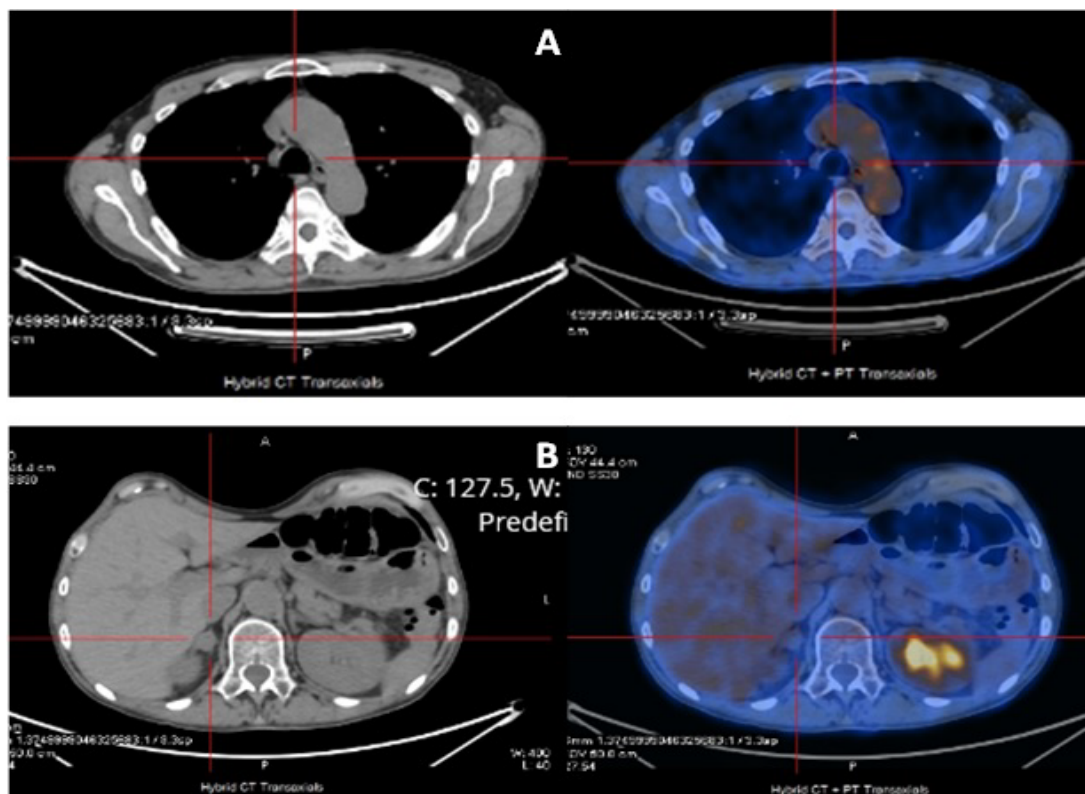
PET/CT images showing complete metabolic response both at the (A) mediastinum and (B) in right adrenal gland with nivolumab therapy.
